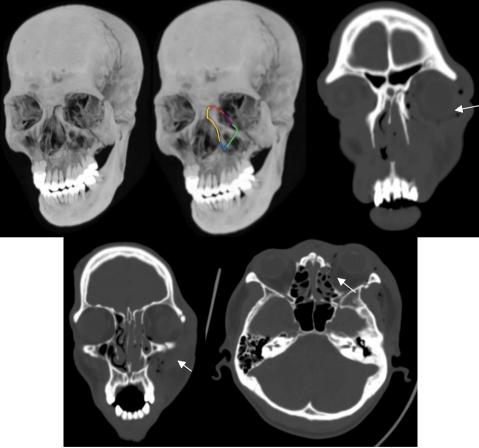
A 38 years old male involved in a motorcycle accident without using helmet with active bleeding from the medial side of the eye but the patient still able to move his left eye. On Axial CT-scan reformat coronal and MIP shows comminuted fracture along the 5-cardinal line: left lateral nose and aperture piriform (yellow line), nasomaxillary buttress (blue line), anterior maxillary wall through orbital floor (green line), medial wall orbital (purple line) and left frontomaxillary suture (red line) which is left side type II NOE fracture (Markowitz and Manson classification). We can also see there is a fracture on the left frontozygoma suture and left temporal and parietal bone.
